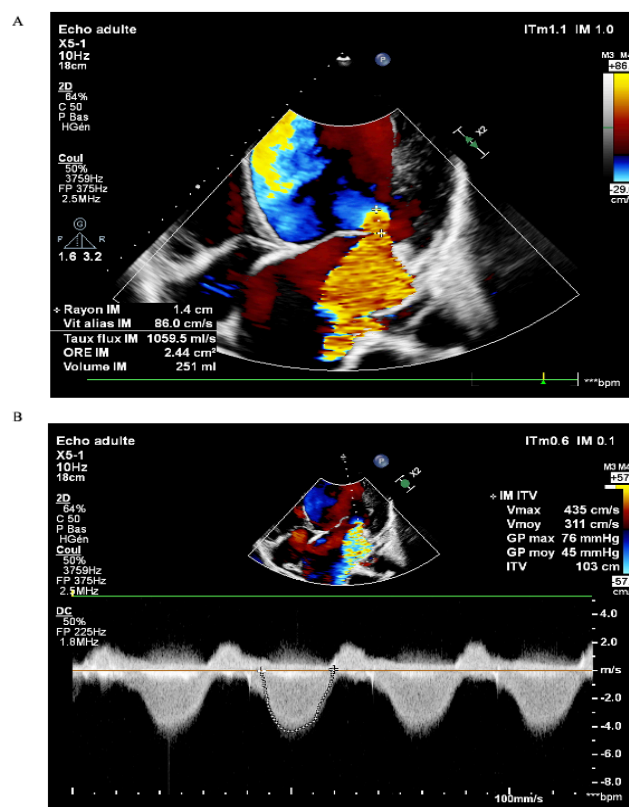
(A-B) Quantitative assessment of torrential mitral regurgitation (PISA and CW Doppler): (A) Color Doppler apical view showing a large proximal isovelocity surface area (PISA) with a measured radius of 1.4 cm and an aliasing velocity of 86 cm/s. The calculated regurgitant flow rate (1059 ml/s), effective regurgitant orifice area (EROA = 2.44 cm²), and regurgitant volume (251 ml) confirm torrential mitral regurgitation. (B) Continuous-wave Doppler tracing demonstrating a dense, triangular, holosystolic jet, consistent with massive mitral regurgitation and markedly elevated left-atrial pressures
